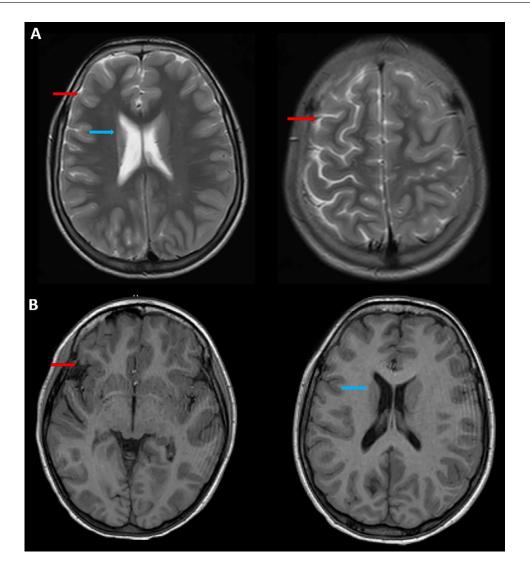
Axial T2-weighted brain MRI (A) reveals exaggerated right hemispheric gyri, indicative of right hemispheric atrophy (red arrow), accompanied by subtle retraction of the ipsilateral lateral ventricle (blue arrow). Axial T1-weighted sequence (B) further demonstrates the enlargement of the sylvian fissure (red arrow) along with atrophy of the ipsilateral caudate head (blue arrow).
